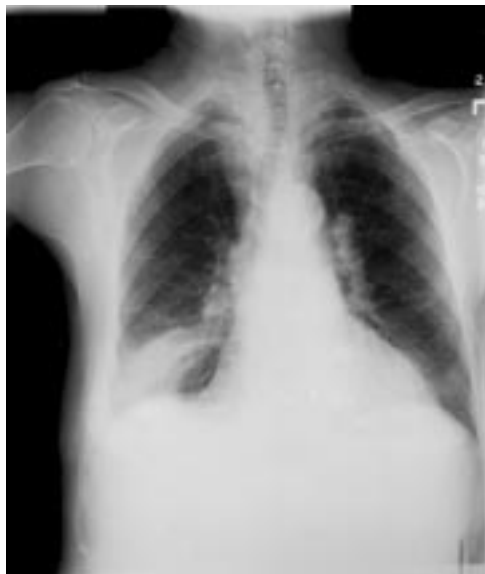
Chest radiograph showing old right lower lung and hilar infiltrates, unchanged from four years before.
